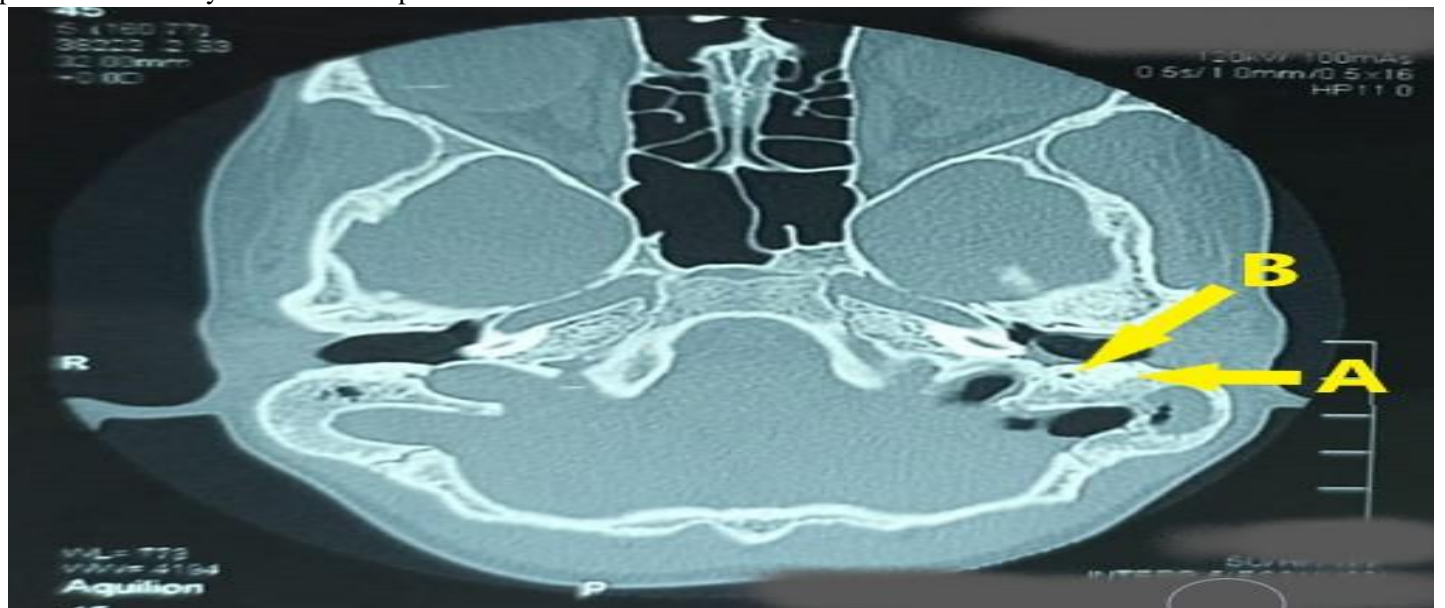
Labrynthitis:The CT Temporal bone axial view suggests Left CSOM, Left mastoiditis (A) with initial stages of ossification of membranous labyrinth (B). The MRI scan of the similar patient shows loss of normal fluid content of the inner ear and enhancement of the membranous labyrinth.
